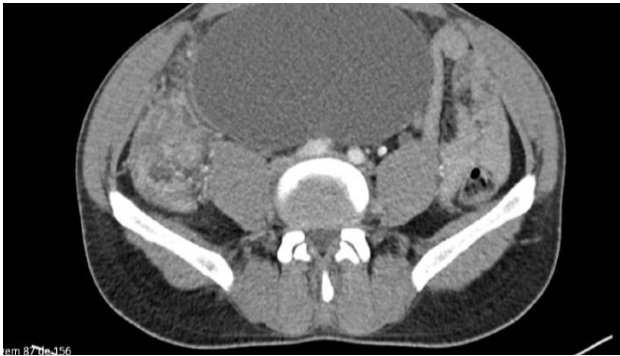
CT confirmed wall thickening of the right colon and a suspected appendiceal plastron.
